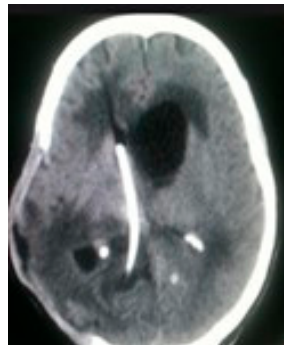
CT scan showing decompressive craniectomy with evidence of a VP shunt. Source: Figure by authors.
